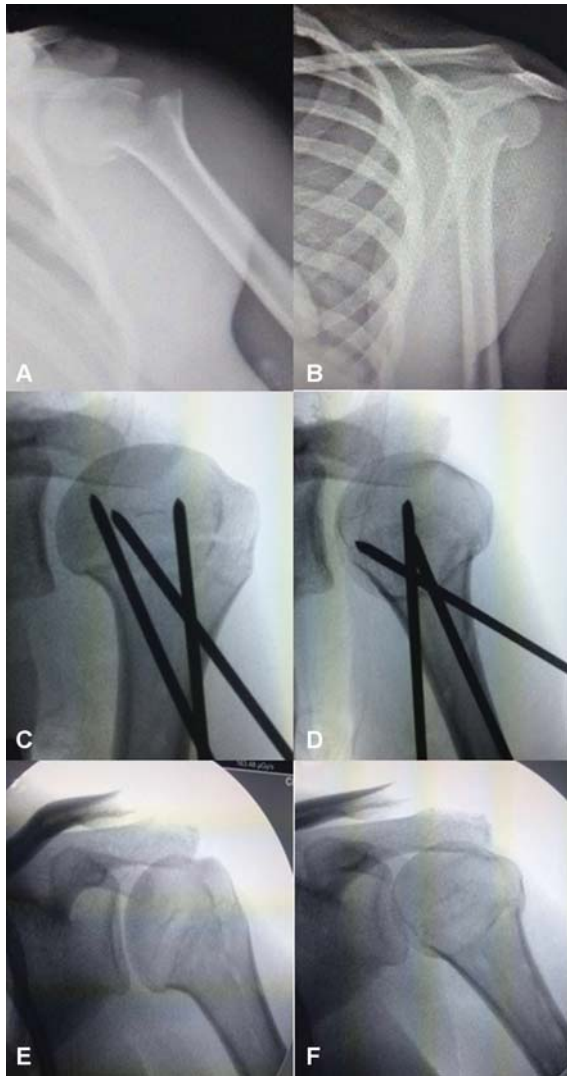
Preoperative radiograph (A); Intraoperative radiographs (B, C, D); Postoperative radiograph after 4 months (E, F, G).
